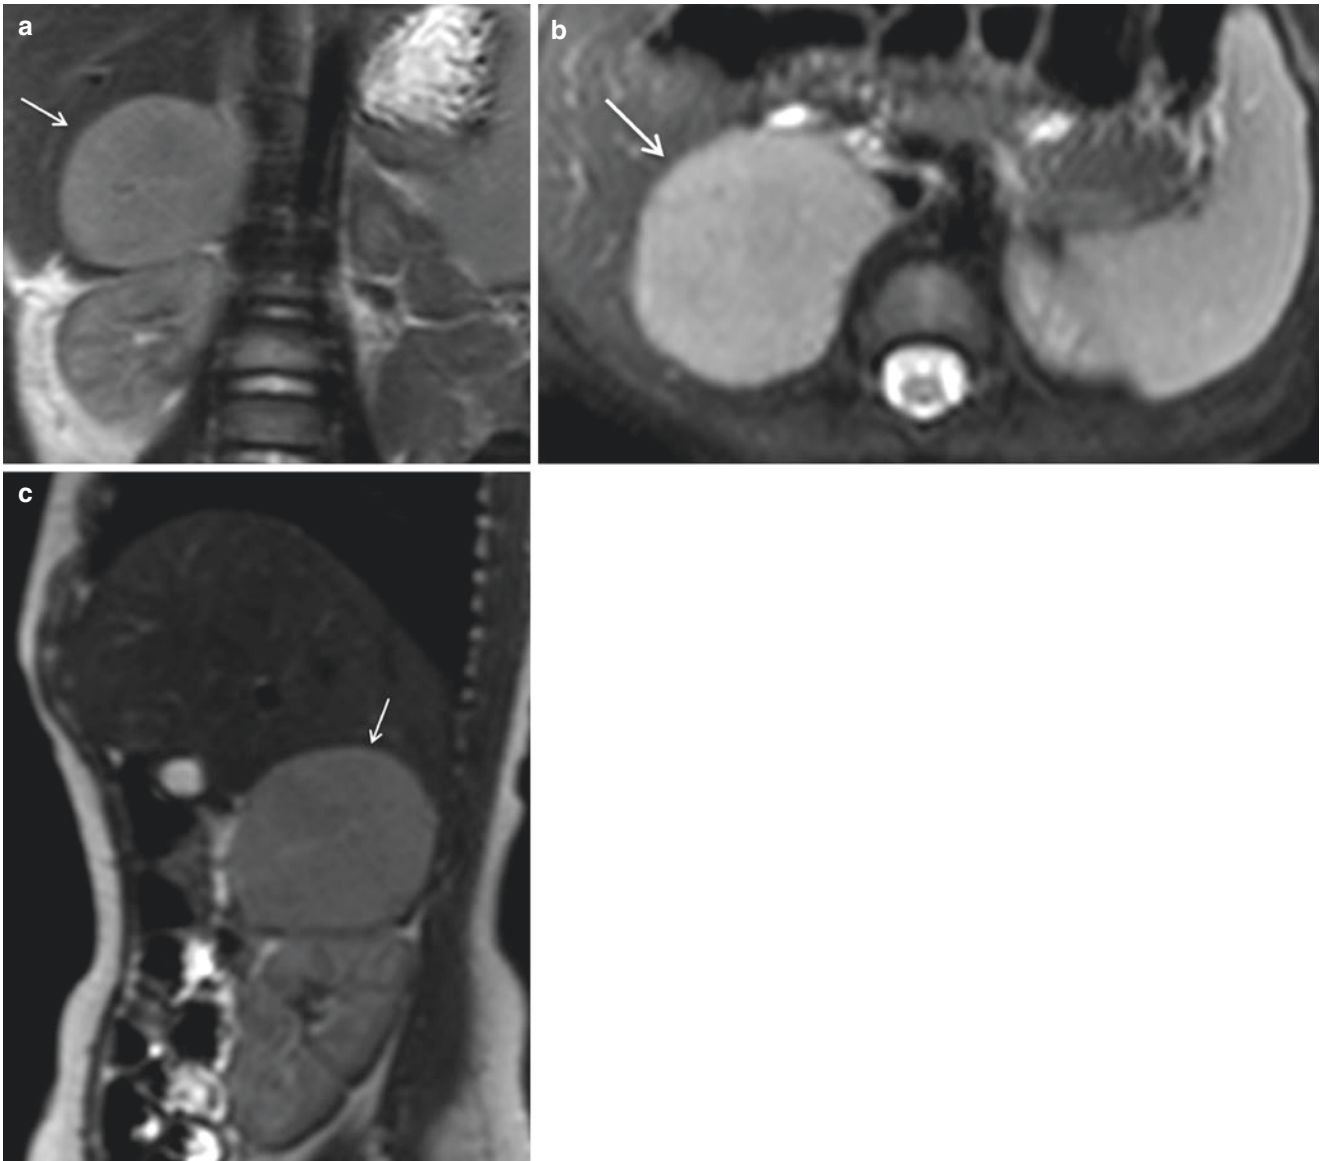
Adrenocortical carcinoma. Coronal (a), axial (b) and sagittal (c) T2-weighted MR images showing a large and homogeneous right adrenal mass in a patient with hyperandrogenism (*white arrows*)
